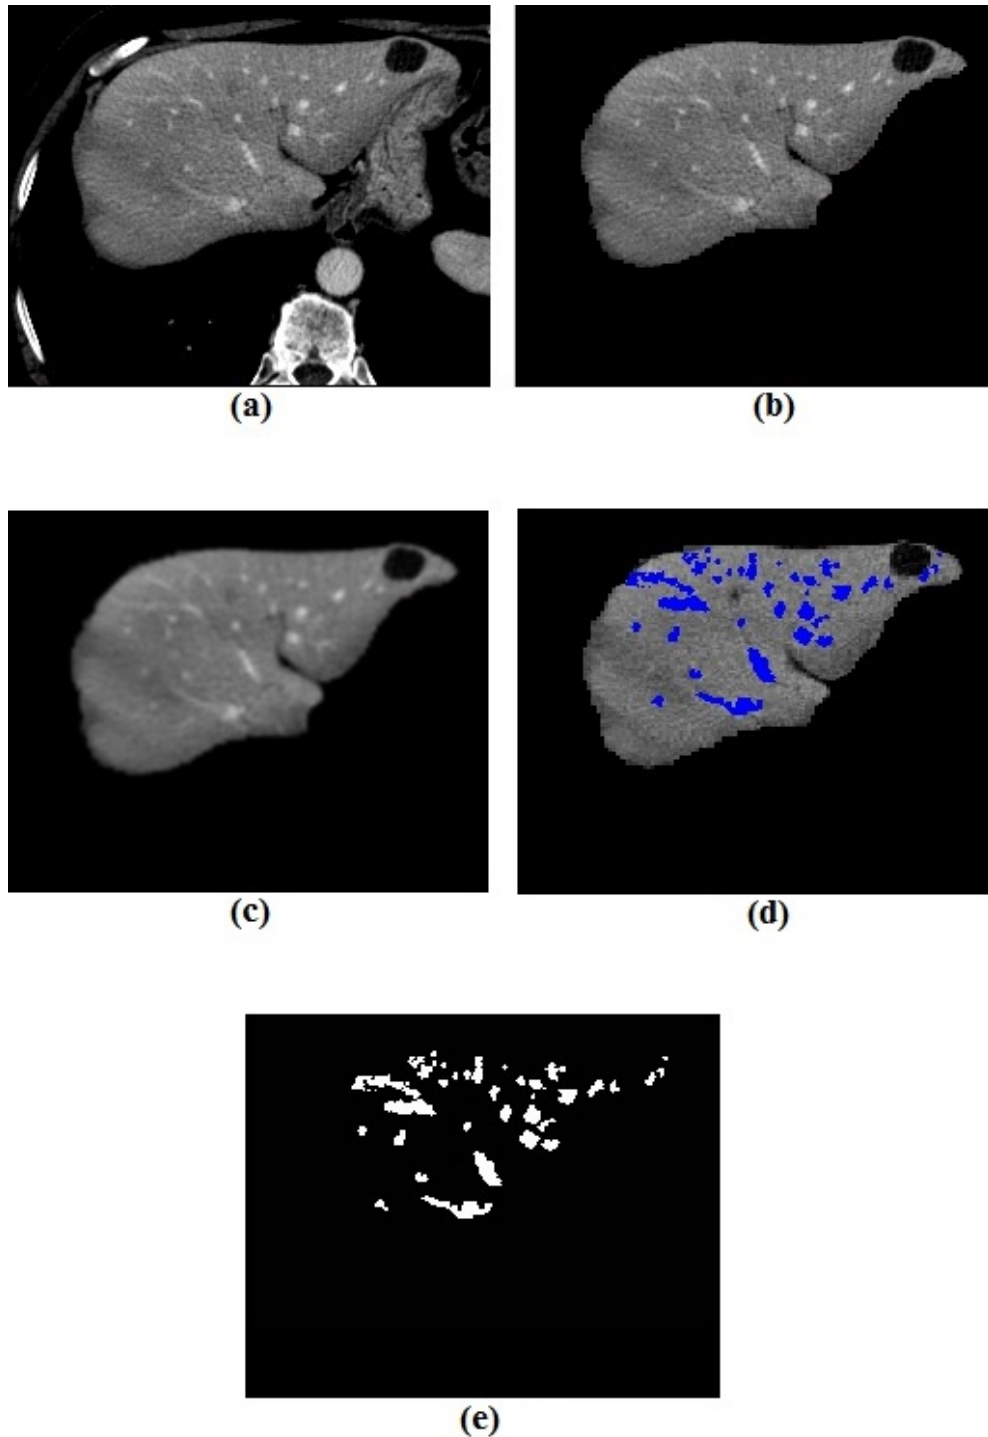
Sample of liver vessels extraction. (a) The original input CT image. (b) The segmented liver. (c) Applies Gaussian filter. (d) Detected liver vessels (blue). (e) Liver vessels mask.
